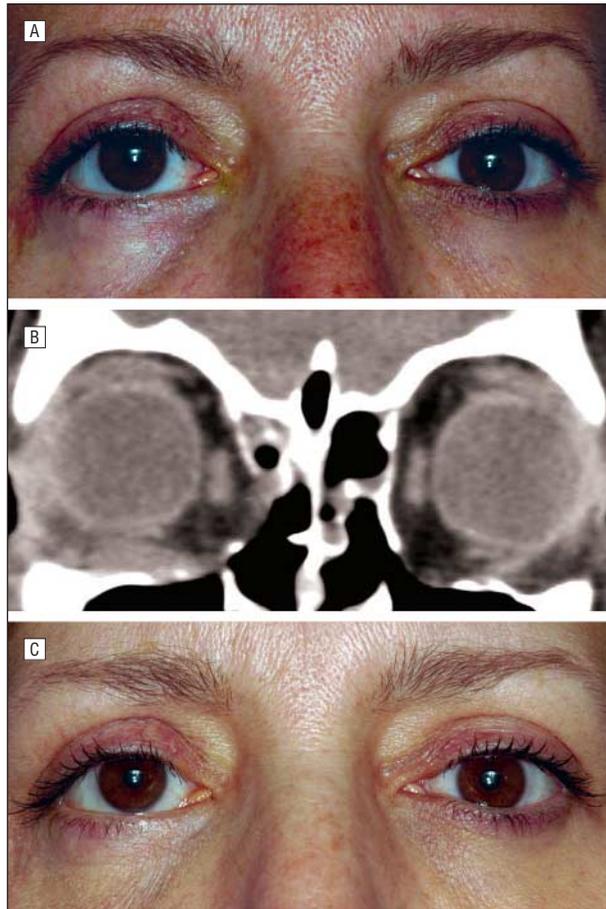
Preoperative right superior globe dystopia and lower eyelid and cheek retraction (A), computed tomographic image showing bony decompression of both orbital floors and medial walls and soft-tissue thickening of the right inferior orbital traumatic neuroma (B), and postoperative improvement of the right dystopia and lower eyelid position (C).
